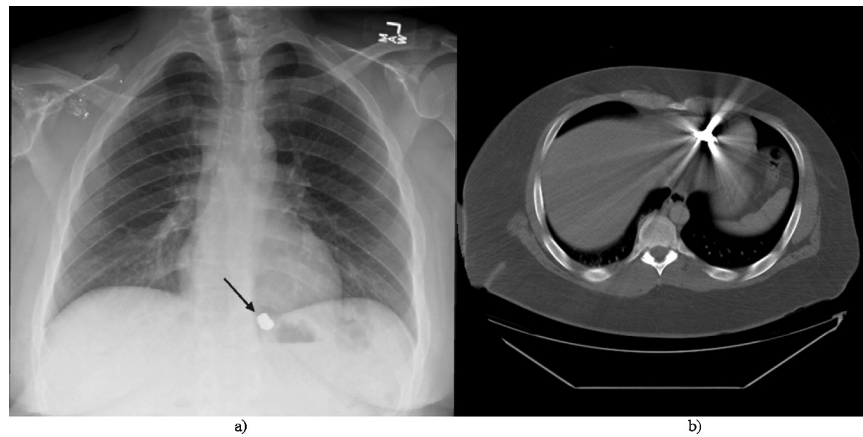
(a) Initial X-ray. (b) CT chest cut demonstrating RV bullet embolism.
